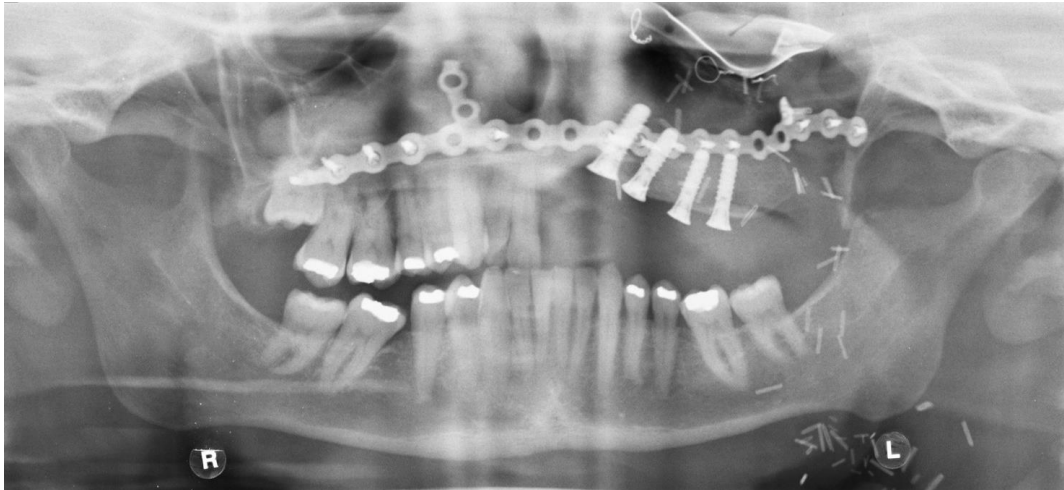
Final OPT radiograph with implant fixtures placed into DCIA ready for prosthodontic reconstruction for the case shown in figure 29.
